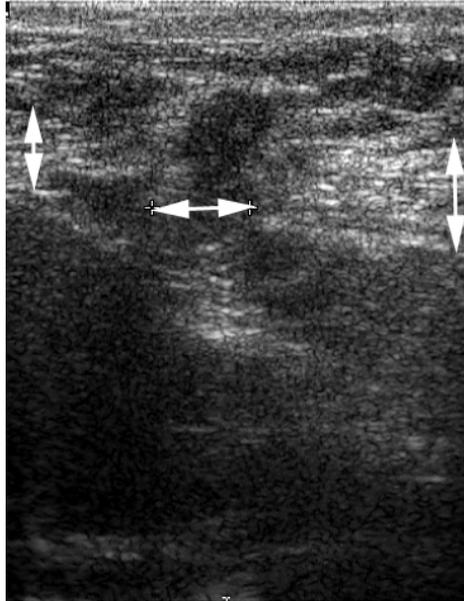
Complete recurrence 2 years after a three-layered direct suture repair of an incisional hernia. Transverse sonogram shows a complete discontinuity (horizontal double arrow) between the two rectus muscles (vertical double arrows) with protrusion of a small hernial sac.
